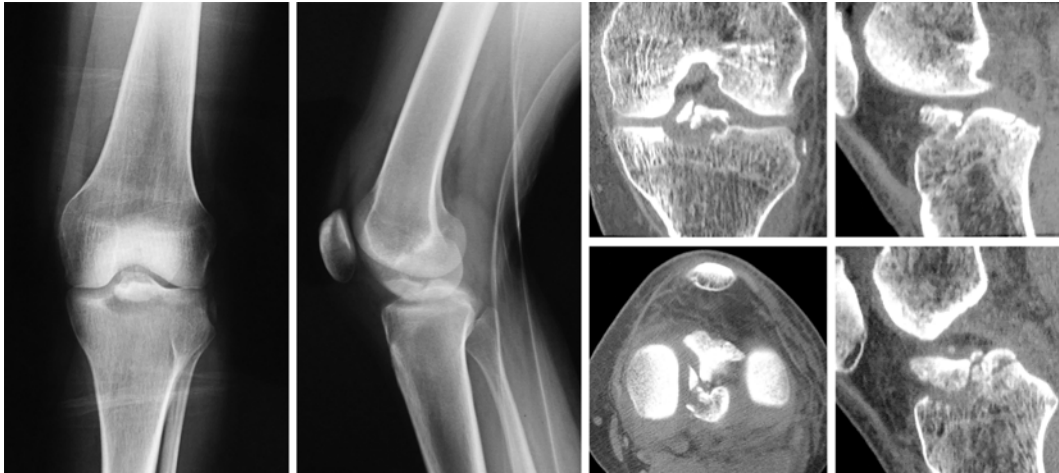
Preoperative radiographs and CT scan in a Meyers and McKeever type III B fracture and Second bony avulsion
